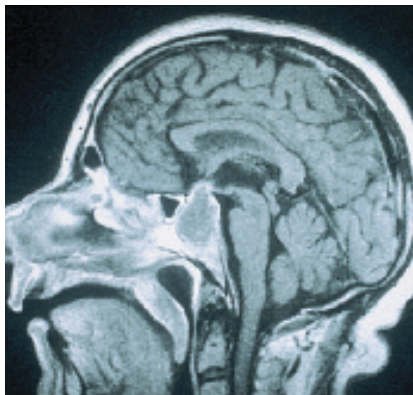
A sagittal MRI of the brain in a case of pituitary apoplexy with sudden visual loss caused by suprasellar extension compressing the optic chiasm from below.
